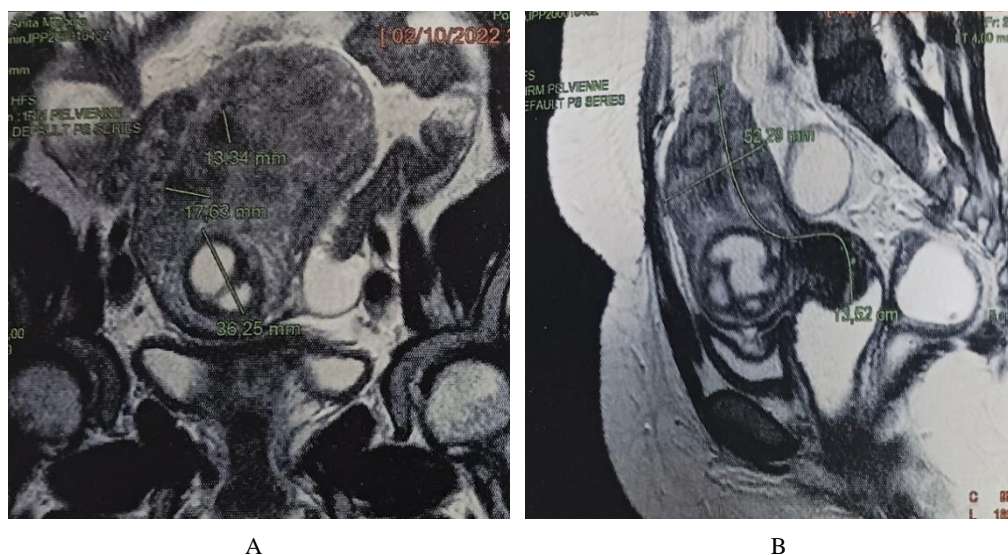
A- Coronal section of pelvic MRI showing a necrotic uterine myoma; B- sagittal section: Respect for the uterine cavity with an image confused with a necrotic myoma.
